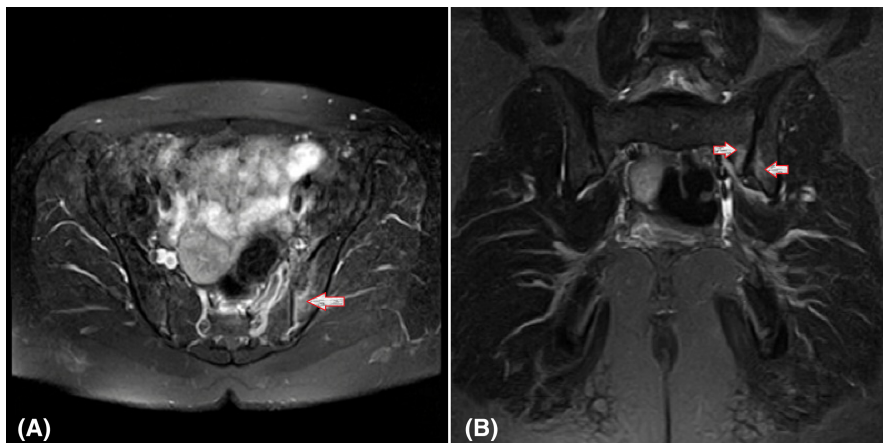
Increased signal intensity on T2-weighted images within and around the left SIJ (A, B) in favor of confirming the sacroiliitis (arrow).
